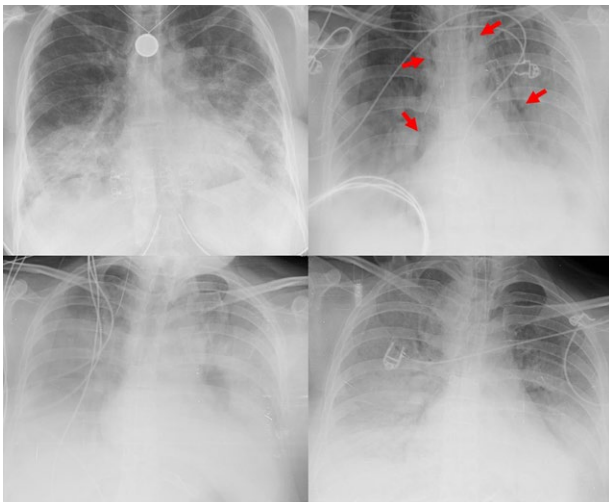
A 33-year-old female patient was admitted to the ICU with COVID-19 and respiratory failure. Chest X-ray images show the early, progressive, and severe phases within two weeks. Also, pneumomediastinum was developed (arrows). And, she died from respiratory failure.
